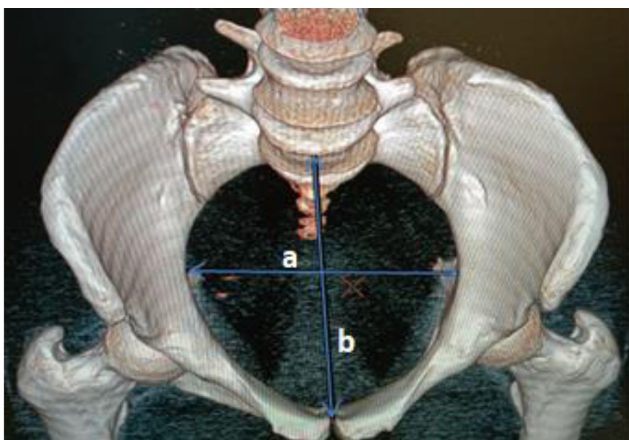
Measurements of the TDI (a) and OCD (b). A reconstructed CT scanned image obtained from the Sodo Christian Hospital's PACS, 2020.
